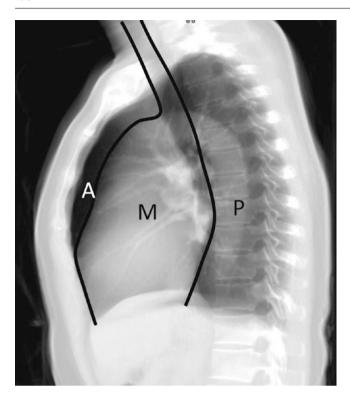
Mediastinal compartments drawn on sagittal thick CT MPR image. *A* anterior, *M* middle, *P* posterior
